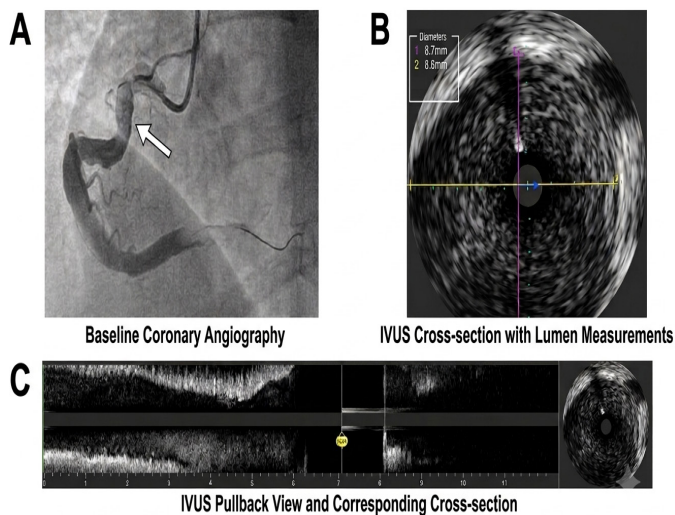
Multimodal imaging of the coronary vessel. (A) Baseline coronary angiography showing a distinct stenosis (white arrow). (B) Intravascular ultrasound (IVUS) cross-sectional image with marked lumen diameter measurements (8.7mm and 8.6mm). (C) IVUS longitudinal pullback map showing the full length of the imaged vessel
